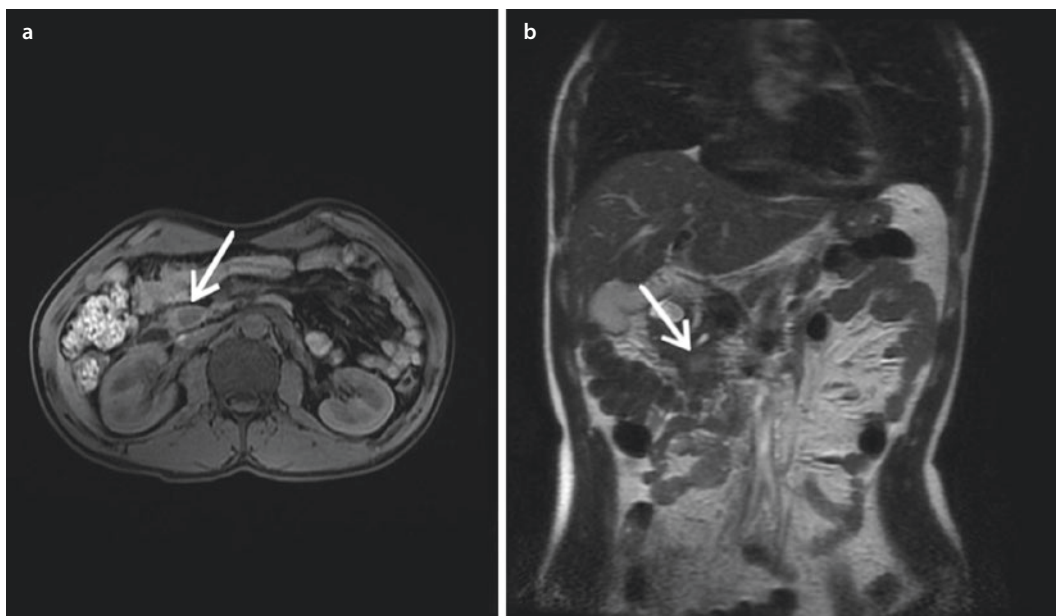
Abdominal MRI: a axial T1 scan—a hypointense mass (arrow) nicely juxtaposed against the T1 hyperintense normal pancreatic parenchyma; b coronal T2 scan—the mildly hyperintense mass (arrow) is
